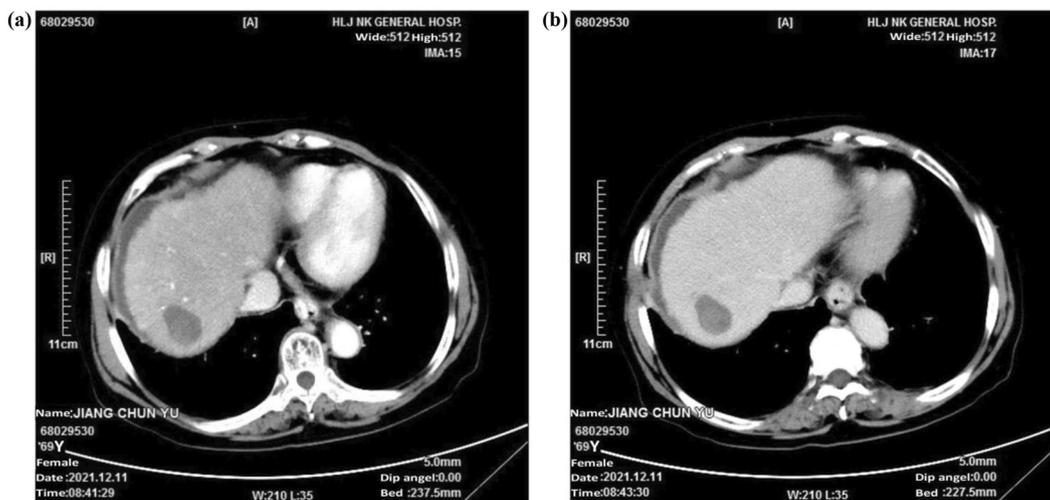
Liver enhanced computed tomography scan after treatment on December 11, 2021. (a) A size of about 21 mm × 28 mm low-density focus can be seen on the right lobe of the liver, larger than before, with slight enhancement in arterial phase which is significantly lower than the surrounding liver parenchyma. (b) Slight patchy enhancement can be seen in the low-density focus of the right lobe of the liver in the portal phase.
